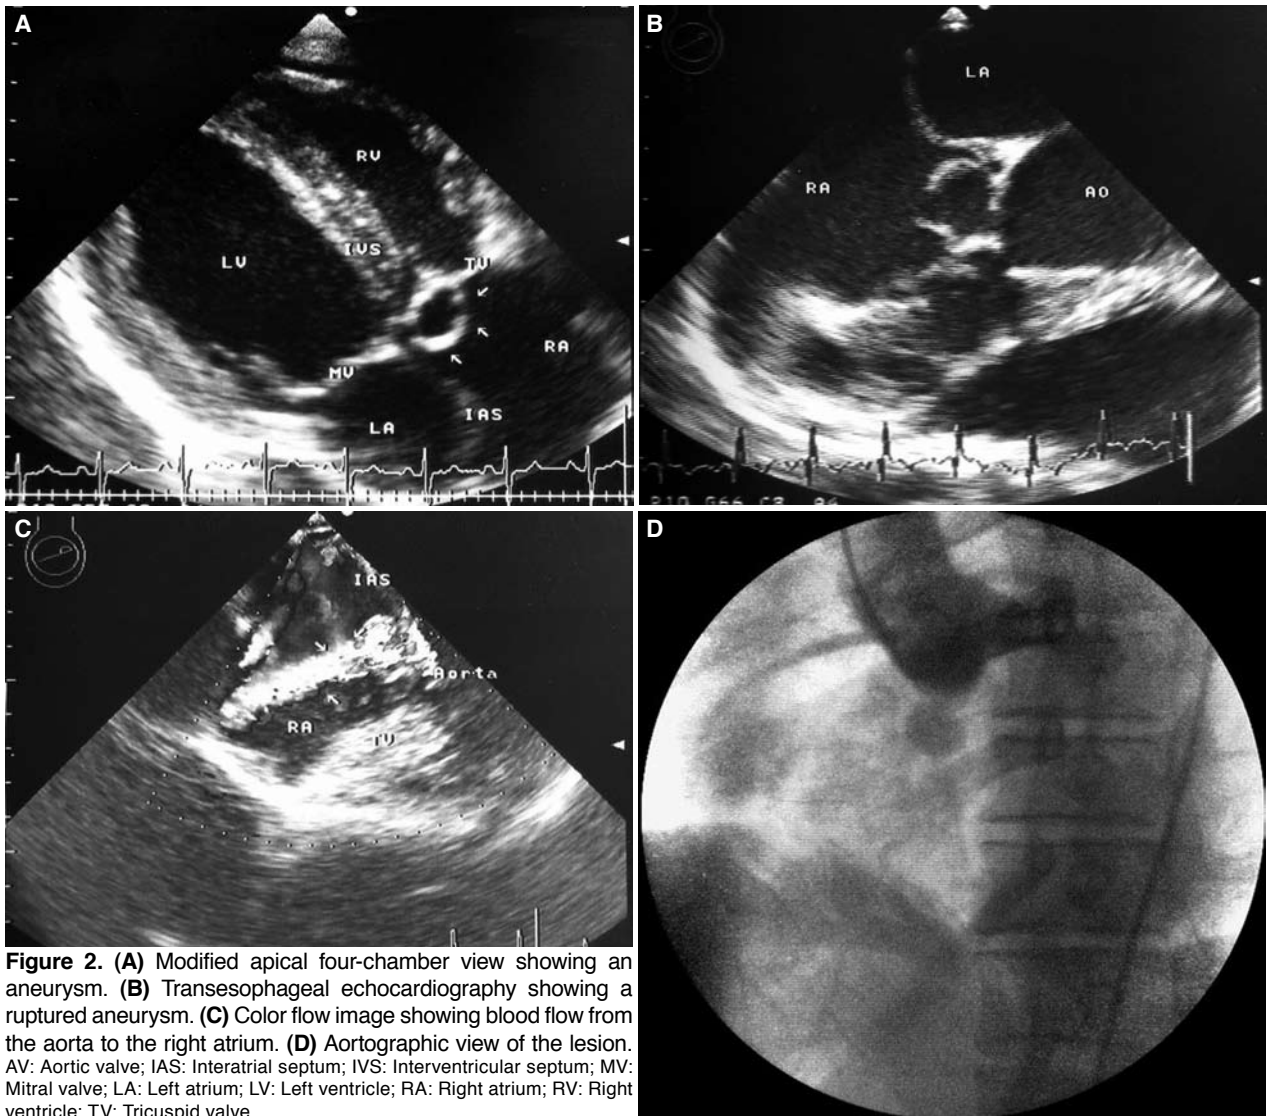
(A) Modified apical four-chamber view showing an aneurysm. (B) Transesophageal echocardiography showing a ruptured aneurysm. (C) Color flow image showing blood flow from the aorta to the right atrium. (D) Aortographic view of the lesion. AV: Aortic valve; IAS: Interatrial septum; IVS: Interventricular septum; MV: Mitral valve; LA: Left atrium; LV: Left ventricle; RA: Right atrium; RV: Right ventricle; TV: Tricuspid valve.
